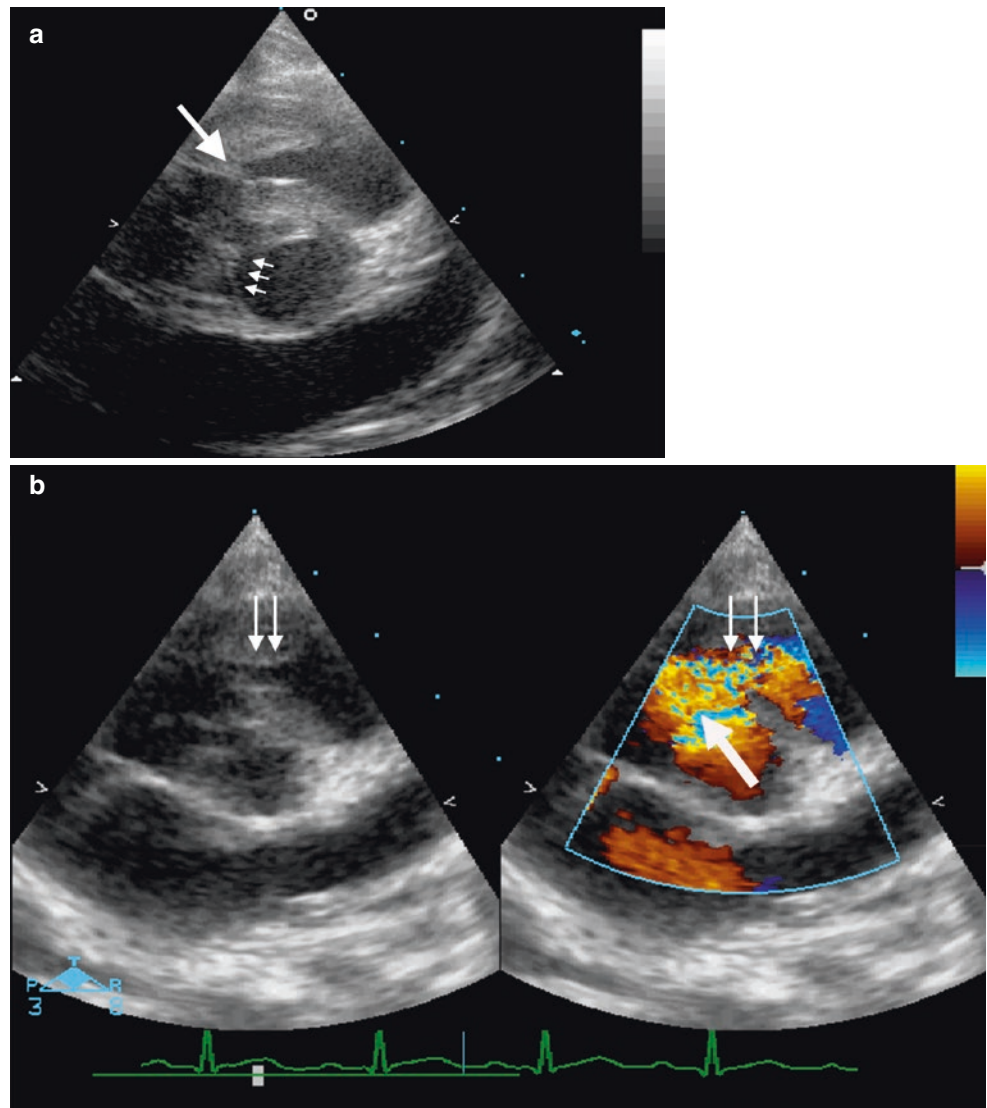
Thickening (*arrow*) of the valve leaflets (subcostal short axis of the right ventricular outflow) in a neonate with severe pulmonary stenosis (a). Colour Doppler in the short axis (b) and in the coronal view shows acceleration of flow starting at valvular level (c). CW Doppler reveals a maximal flow velocity of 4,96 m/s corresponding to
